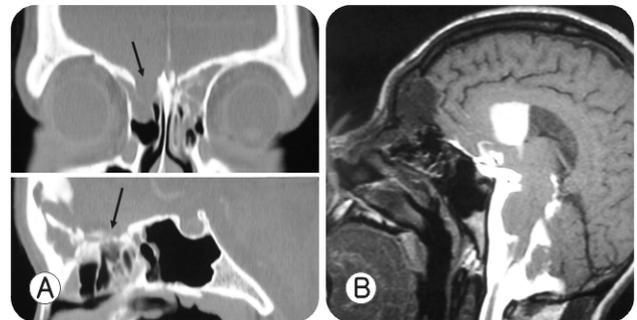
A. Plain CT scan showing opacification of the ethmoid sinus due to trapped CSF with bony dehiscence at the roof of the ethmoid sinus. B. Gd-DTPA MR cisternography did not delineate the exact defect site.
